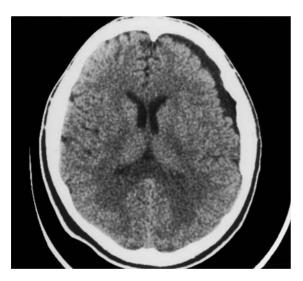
Posttraumatic subdural hygroma. The axial CT shows a left sided frontal posttraumatic subdural hygroma.
